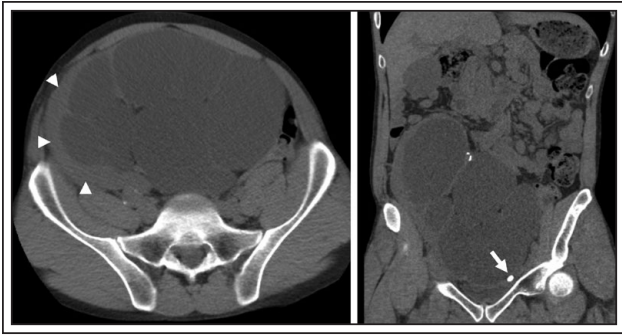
CT of the abdomen and pelvis without contrast demonstrates a right lower quadrant renal allograft with massive dilation of the collecting system and thinning of the renal parenchyma (arrow heads). A 7.3 x 8.5 mm calculus is identified in the distal ureter and observed on the coronal image (arrow).
